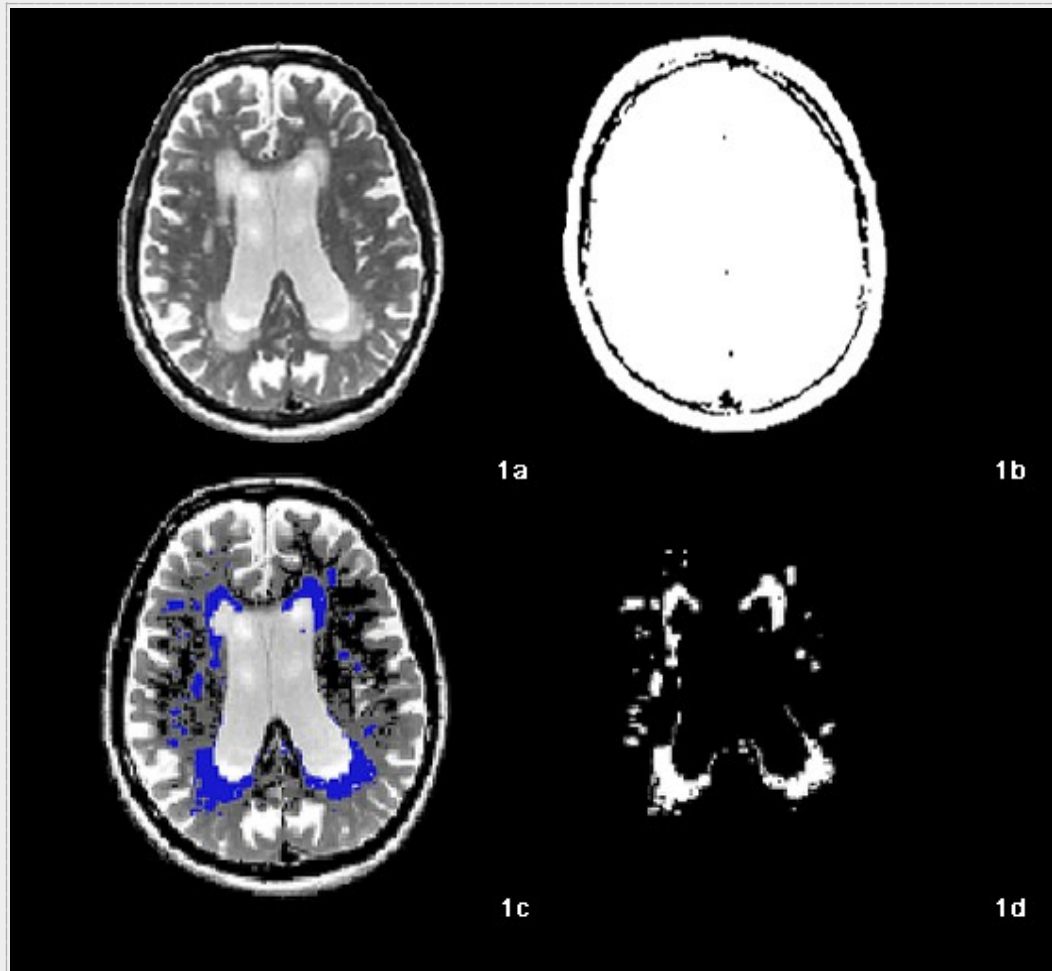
Example of WMH extraction from T2-MRI for the AddNeuroMed cohorts; slice from an AddNeuroMed subject with extensive caps of WMH and punctuate lesions extracted with BRIC: (1a) T2 MRI volume; (1b) brainmask; (1c) WMH in blue overlay on a T2 volume; and (1d) segmented WMH.
